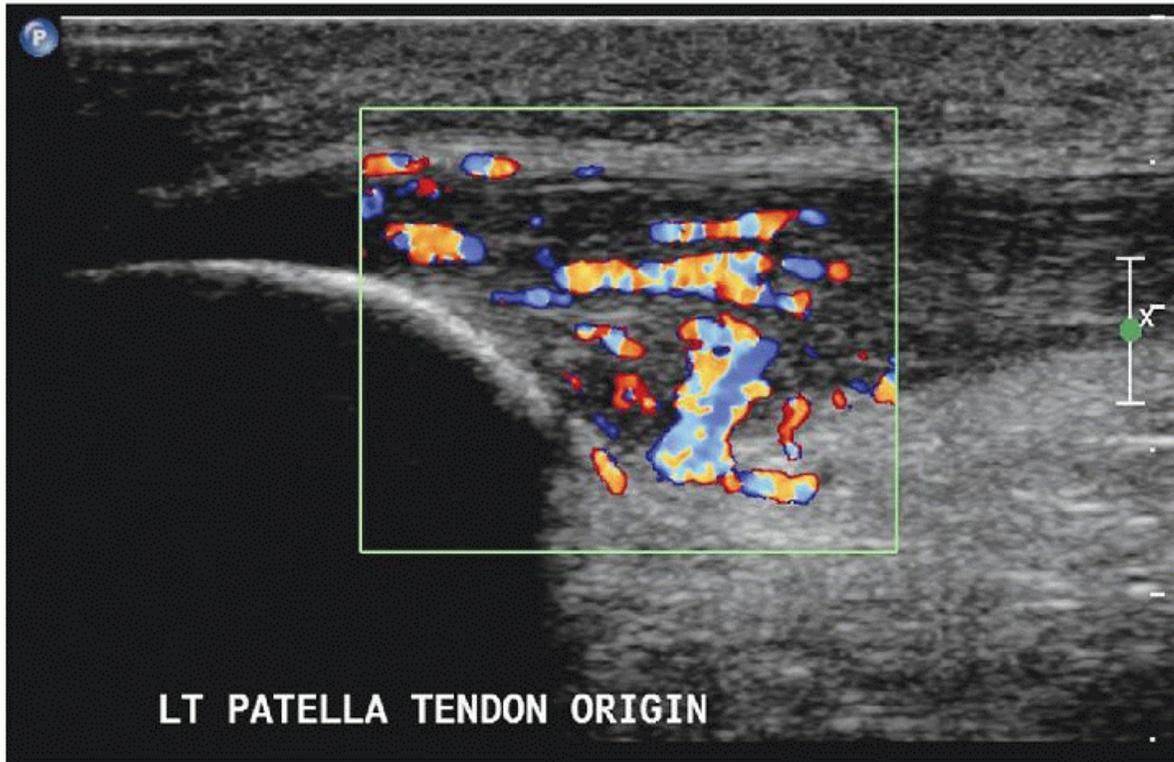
Longitudinal color Doppler image of the proximal patella tendon demonstrating severe tendinosis with marked hyperemia.
